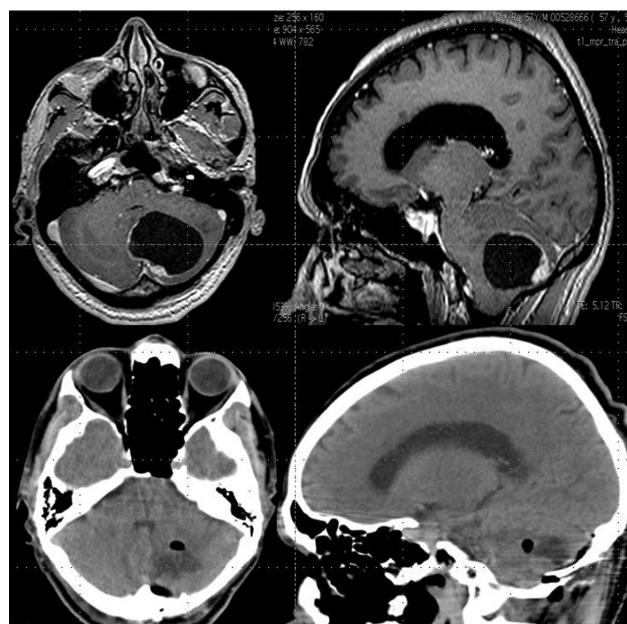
(A and B) Preoperative axial and sagittal T1 contrast magnetic resonance imaging showing large cystic tumor with enhancing nodule in the left cerebellum. (C and D) Postoperative axial and sagittal plain computed tomography images showing complete excision with no tumor bed hematoma.
